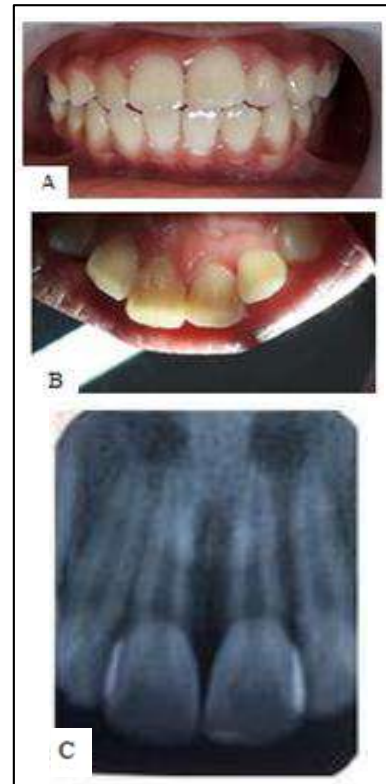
A. Labial surface post restoration Class IV teeth 21 after 6 months. B. Palatal surface post restoration Class IV teeth 21 after 6 months. C. Periapical radiograph after 6 months.
